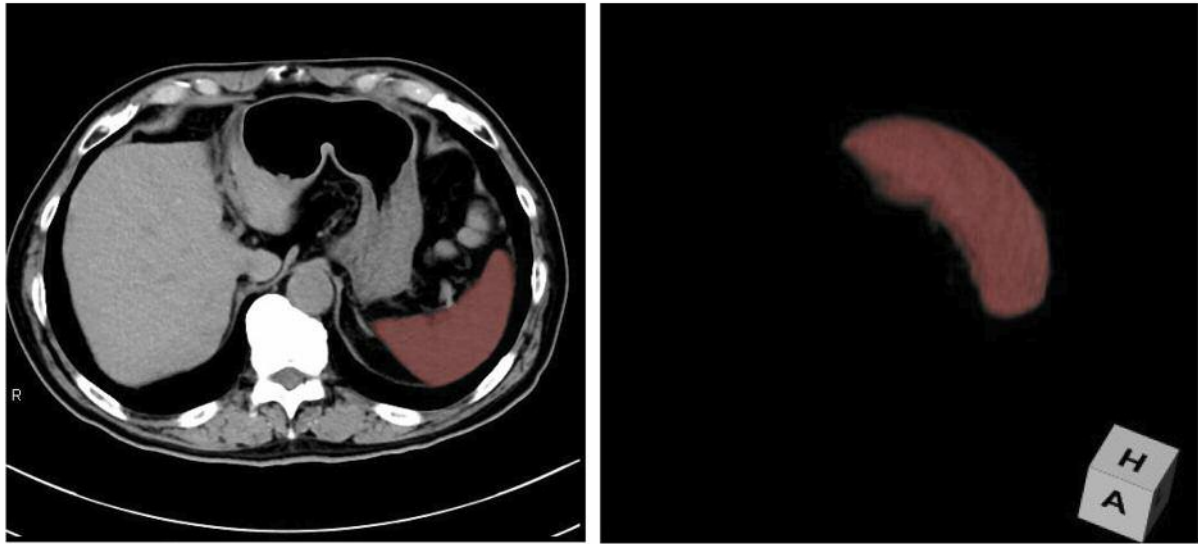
Representative images of splenic volume. Splenic volume was measured using the calculator software Ziostation 2® (Zaiosoft, Tokyo, Japan), which can provide highly accurate measurements. The accurate three-dimensional image on the right was derived from the brown-colored area in the computed tomography image on the left.
